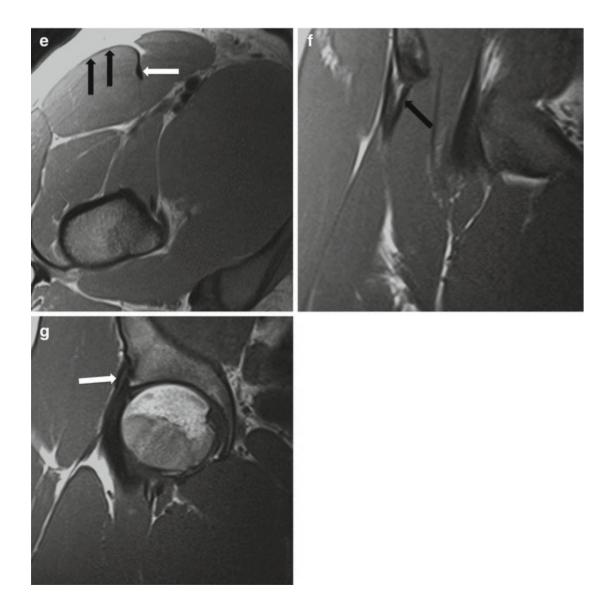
A healthy 15-year-old male athlete with normal MRI anatomy of the proximal right rectus femoris. (a–e) Axial T1-weighted MRI. (a) The direct head inserts at the anterior inferior iliac spine (black arrow) while the indirect head is slightly more posterior inserting at the superior ridge at the anterolateral aspect of the acetabulum (white arrow). (b) The indirect tendon is seen in its full horizontal oblique course (white arrows) and is immediately posterior to the direct tendon (c) Slightly caudally both tendons merge into the conjoint tendon (arrow). (d) The rounded tendon progressively flattens as it travels distally, lying in the most medial aspect of the muscle (arrow). (e) While progressing along the muscle, fibers from the direct tendon form the superficial tendon (black arrows) and those continuing the indirect tendon migrate to a sagittal position (white arrow). (f, g) Coronal T1-weighted MRI show the insertion of the direct head off the anterior inferior iliac spine (black arrow) and the attachment of the indirect head to the superior acetabular ridge (white arrow)
